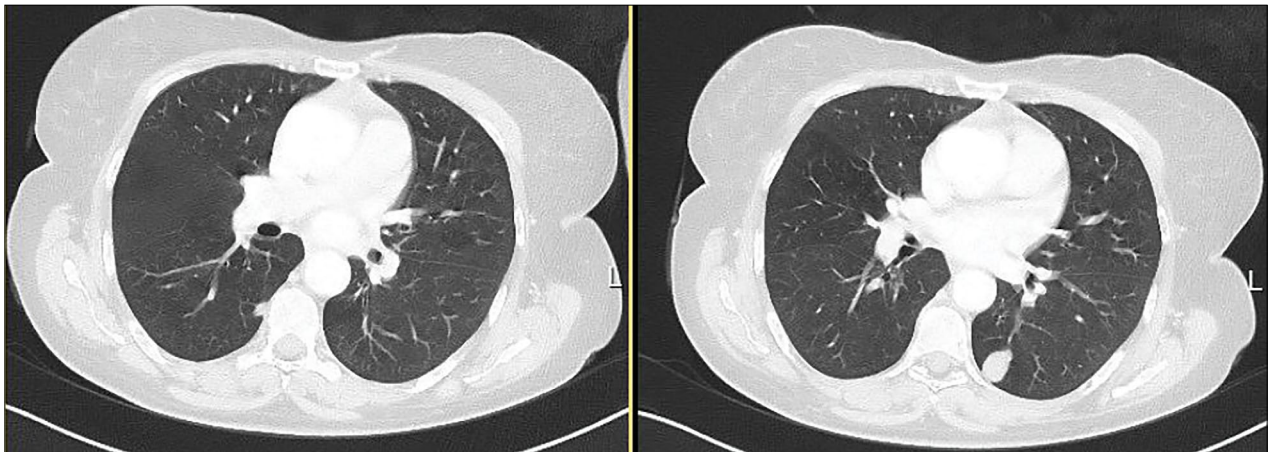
Two paravertebral pulmonary nodules with a smooth margin, one 20x15 mm in diameter, in the left upper lobe apicoposterior segment, other 7 mm in short axis, in the right lower lobe superior segment in thorax CT.
